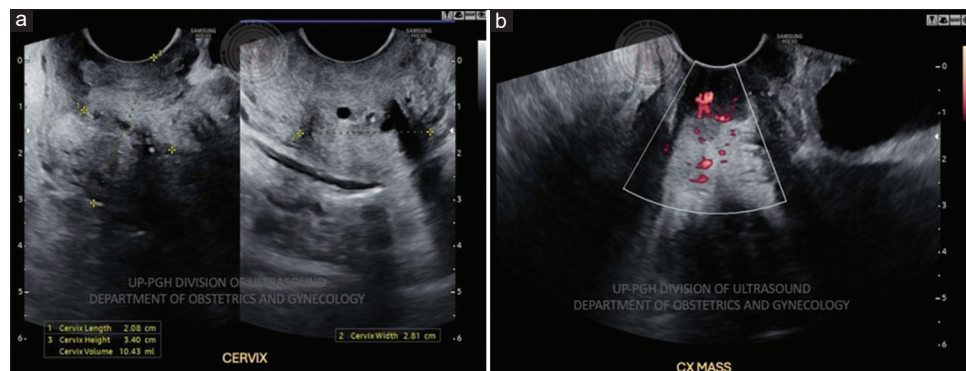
Transvaginal ultrasound: (a) There is an irregular, hypoechoic, exophytic mass measuring 2.7 cm × 2.4 cm × 1.5 cm (volume: 5.1 cc) at the lower third of the anterior cervical lip. (b) Power Doppler of the cervical mass shows moderate branching vascularity (Color score = 3)
